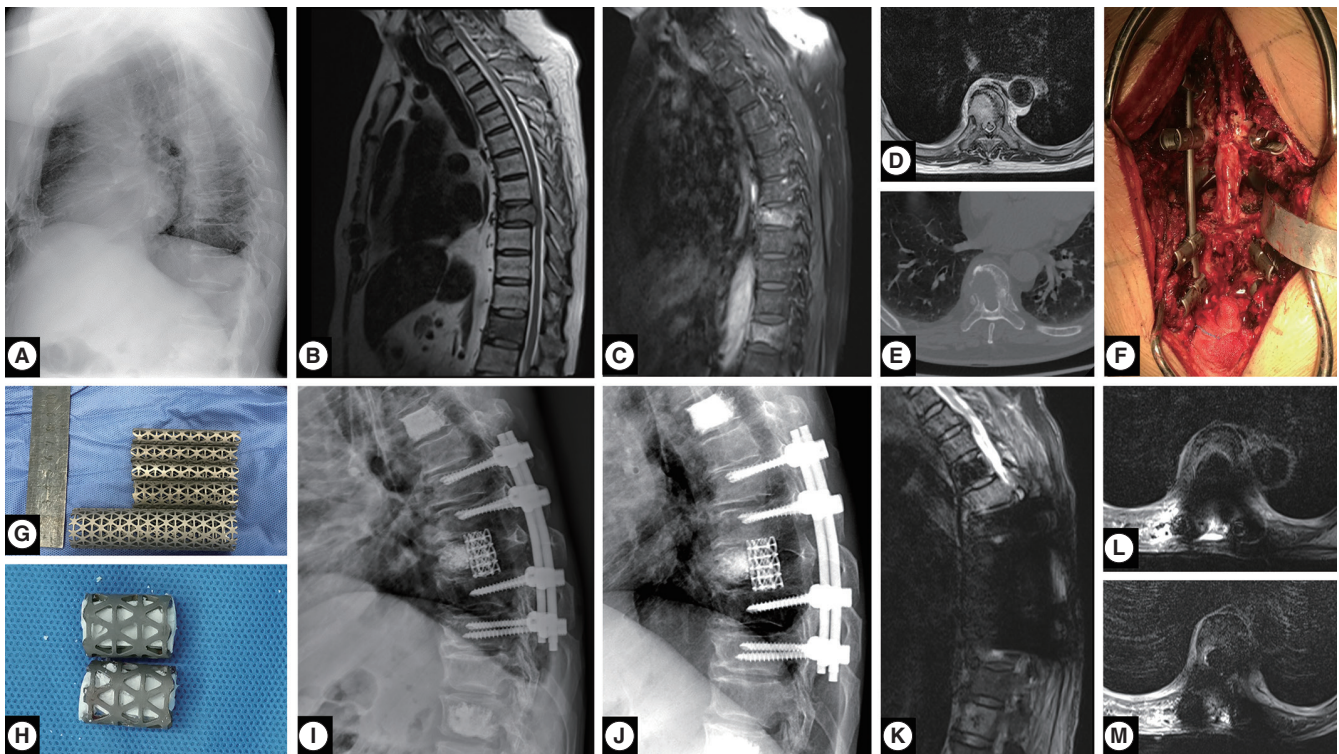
A 67-year-old female patient (case #33) was admitted with motor dysfunction and mild back pain. (A) Preoperative plain radiographs reveal compression of the eighth thoracic vertebra. (B–D) To further clarify the cause of vertebral compression and observe any neurological involvement, an enhanced magnetic resonance imaging (MRI) was ordered for the patient. Through MRI, we noticed abnormal long T1 and long T2 signals in the eighth and twelfth thoracic vertebra, with significant enhancement on the contrasted sequence. Meanwhile, we noticed high signal intensity in corresponding thoracic spinal cord, and nodular high signals at the level of thoracic vertebrae 4–7, with significant enhancement on the contrasted sequence. (E) Through preoperative computed tomography, we noticed an eccentric lytic lesion without calcification inside the tumor. (F) A total *en bloc* spondylectomy was performed at the T8 level, while vertebroplasty was performed in T4 and T12. (G, H) Two appropriately sized titanium mesh filled with morselized artificial bone graft were inserted via bilateral corridors without traction of the nerve roots or the dural sac. (I) Postoperative plain radiographs demonstrated satisfactory alignment and restoration of intervertebral height. (J–M) Follow-up evaluation at 1 year showed no instrumentation failure or local recurrence.
